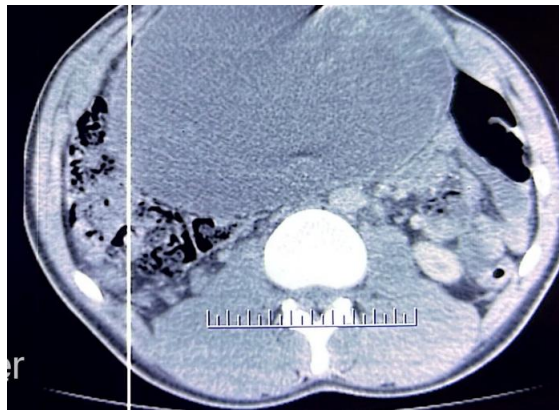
CT image showing an intraperitoneal cystic formation
